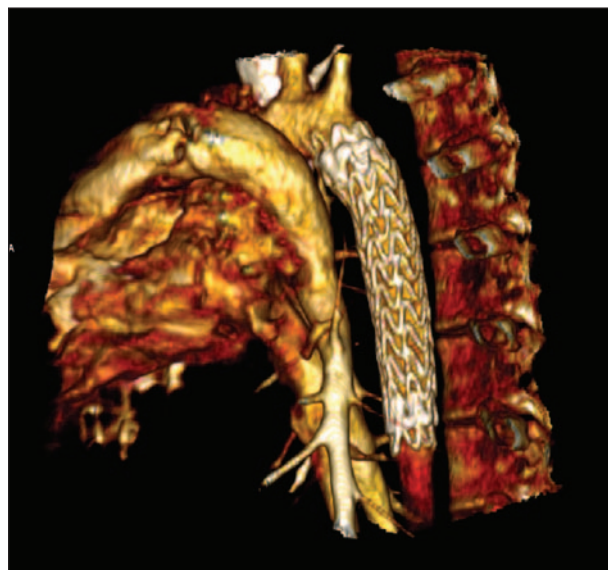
Intraoperative 3D volume rendering of EM-tracked thoracic stent graft after CT angiography. Image generated intraoperatively with OsiriX imaging software.
